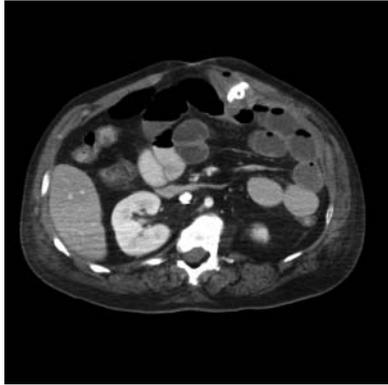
Postintravenous contrast axial abdominal CT image. This demonstrates the transition point in the small bowel caused by the percutaneous endoscopic gastrostomy flange.
